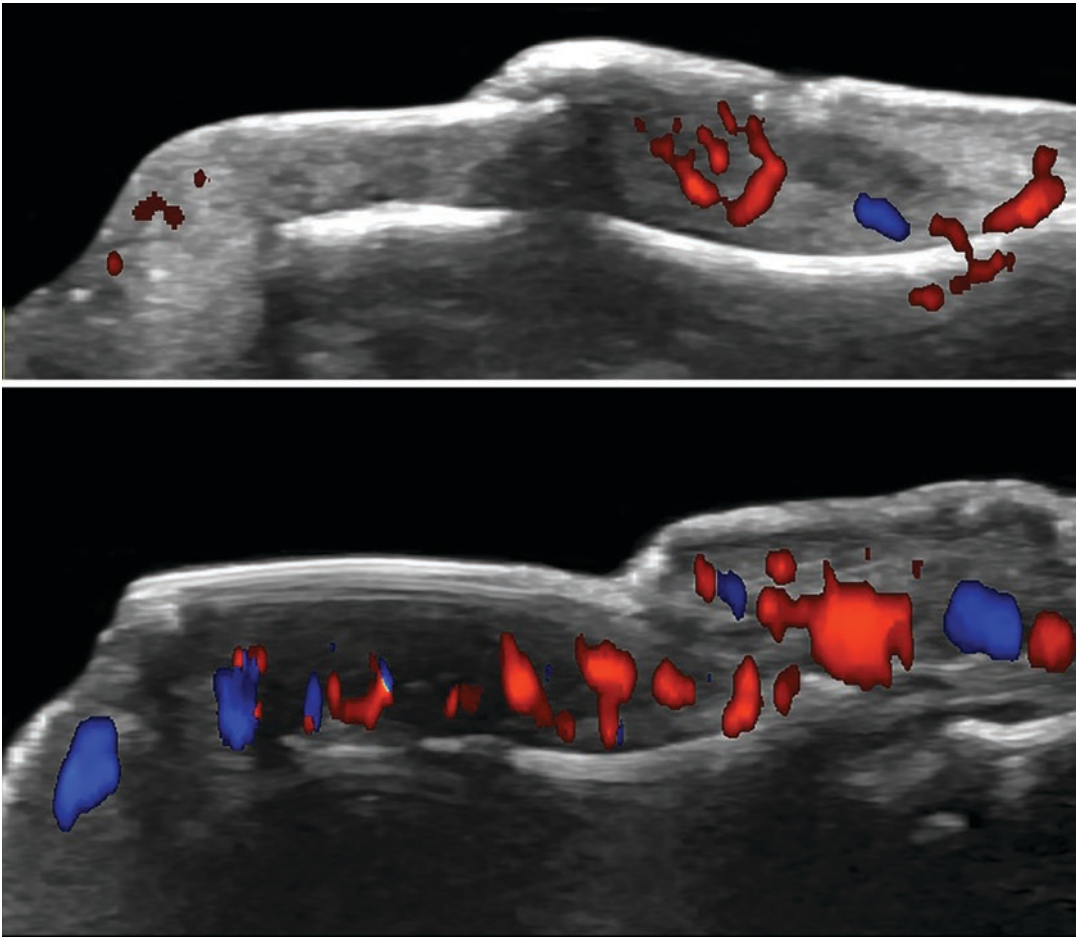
Psoriasis. Color Doppler ultrasound grading of vascularity in psoriatic onychopathy
